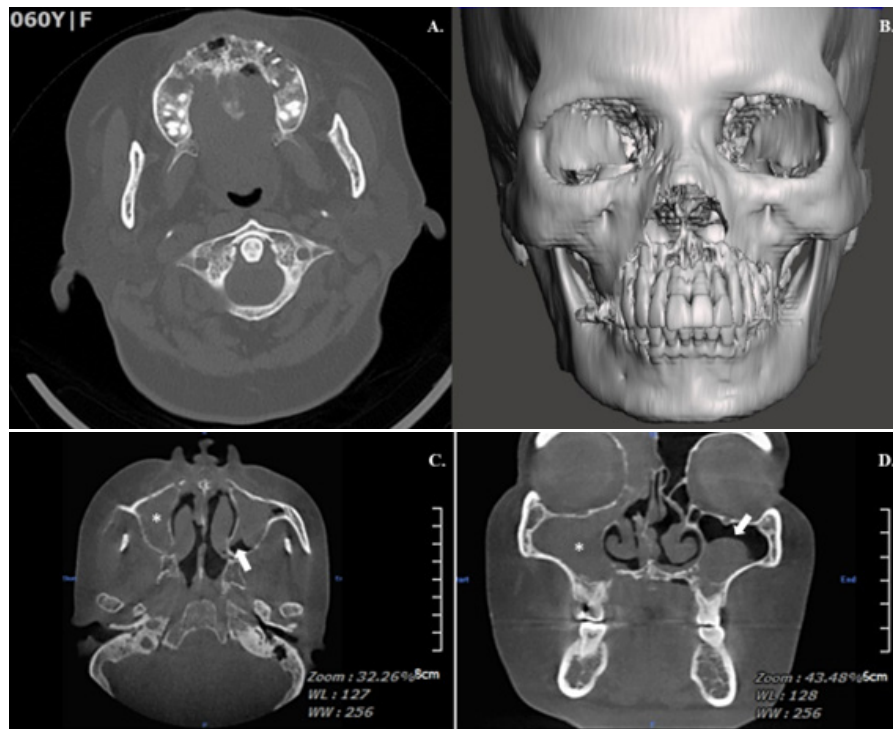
Computed tomography A) axial view B) 3-dimensions showing areas of bone erosion with multiple air foci and hypodense collection in marrow cavity. C) axial view D) coronal view, presented complete obliteration of the right maxillary sinus (depicted by the white asterisk), partial obliteration of the left maxillary sinus exhibits (indicated by the white arrow).
